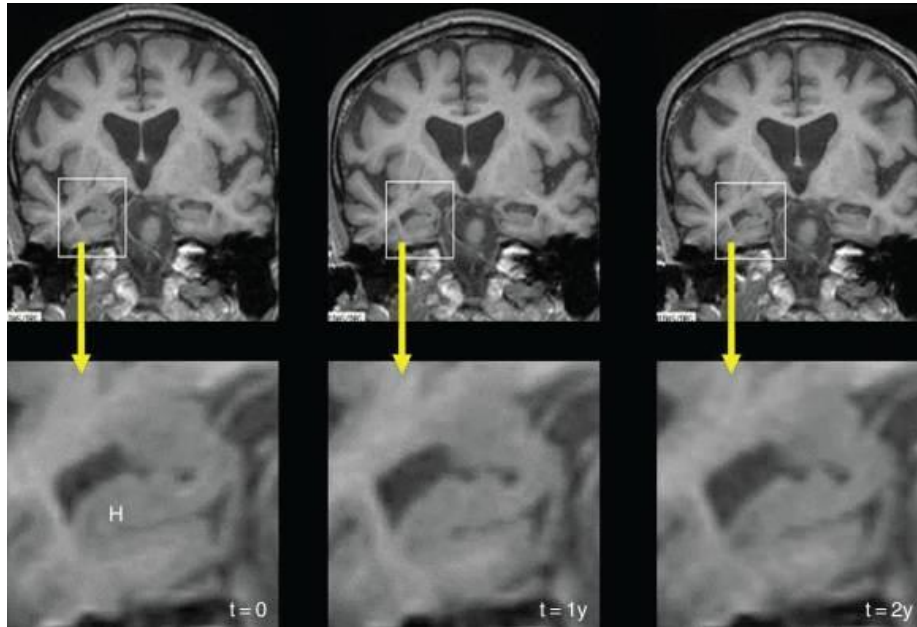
This series of three coronal T1-weighted studies, from an individual with autopsy-proven Alzheimer disease (AD), were each acquired 1 yr apart and show progressive hippocampal (H) atrophy as the individual progressed from memory complaints (*left* column, $t = 0$) to MCI (*center*, $t = 1y$) and on to fulfill criteria for AD.
